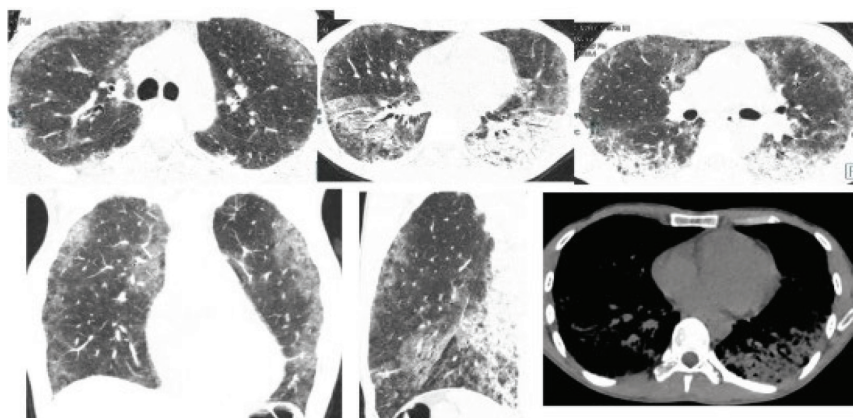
High-resolution CT images show patchy subpleural ground-glass opacities throughout both lungs and alveolar consolidations in both lower lobes. CT, computed tomography.
